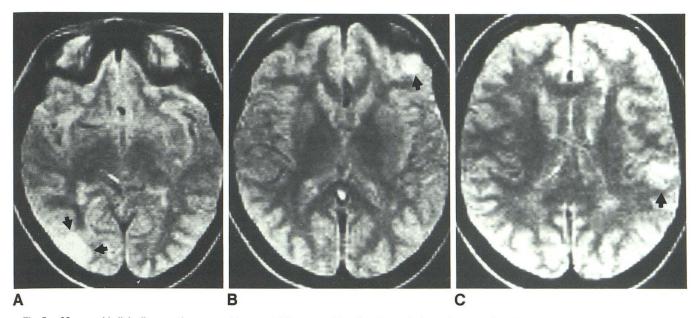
32-year-old clinically normal woman, with normal CT scan, and her daughter, who has tuberous sclerosis. A-C, SE 2000/56, 256  $\times$  128 matrix. Transaxial images at three levels show three areas of increased signal in cortex (*arrows*).
